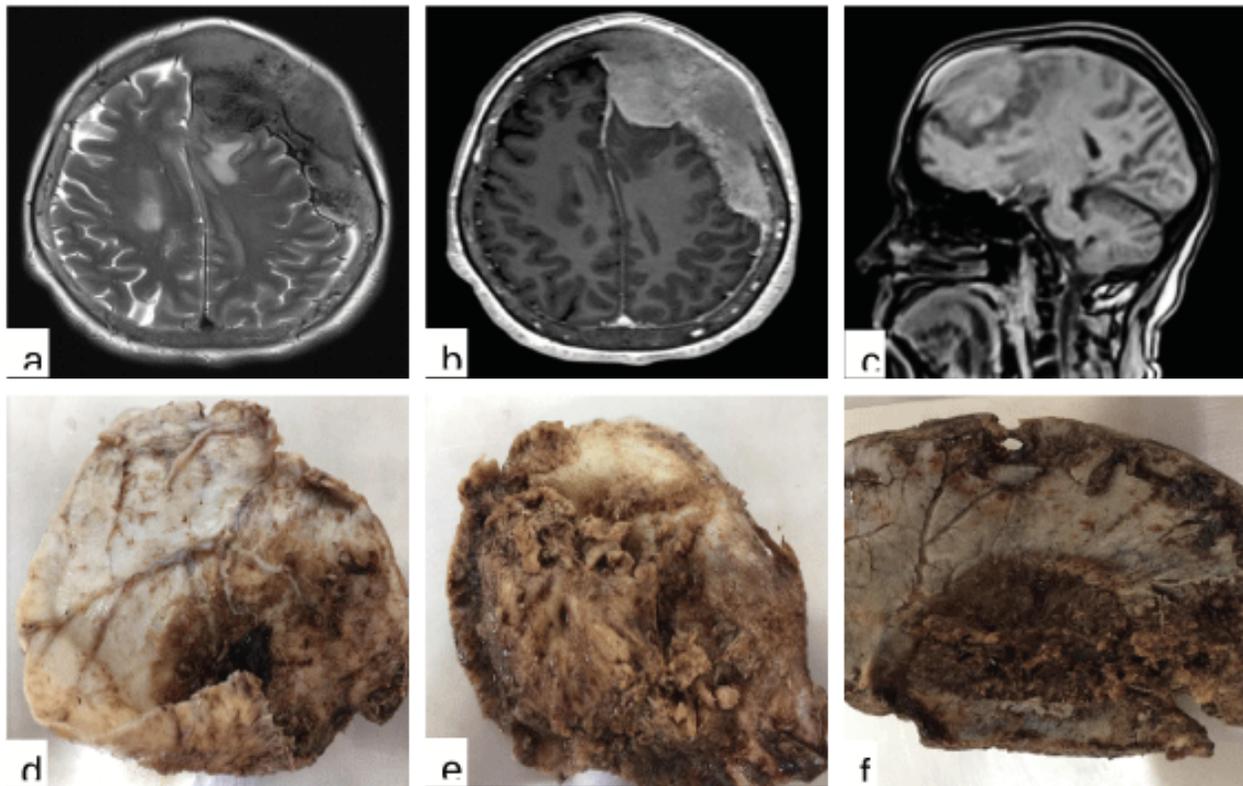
Shows the radiological images of the lesion. (a) MRI in T1 coronal section shows the intra and extra dural meningeal lesion. (b) MRI in T2 coronal section shows a hyperintense heterogeneous lesion. In (c) Sagittal section we observed nodular lesion with extensive perilesional edema. (d) Macroscopic appearance of the lesion, which corresponds to an irregular segment of dura mater on the external part that measured 12x10x10mm, diffusely infiltrated by a clear to yellowish-brown neoplasm and in (e) through the convexity this was white with a rubbery appearance, firm, and in the central portion there was a diffuse lesion raised granular clear coffee that measured 60x50x20mm, and in (f) we observed fragment of calotte of the frontal region that shows an infiltrating neoplasm, high, gray-brown, granular and soft.
